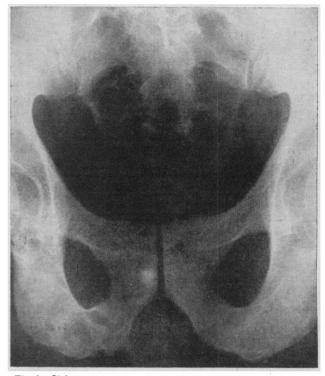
Plain roentgenogram of prostatic area showing compact calculus lying behind right publs. Rectal palpation had disclosed hard localized nodule in right lobe of prostate.
